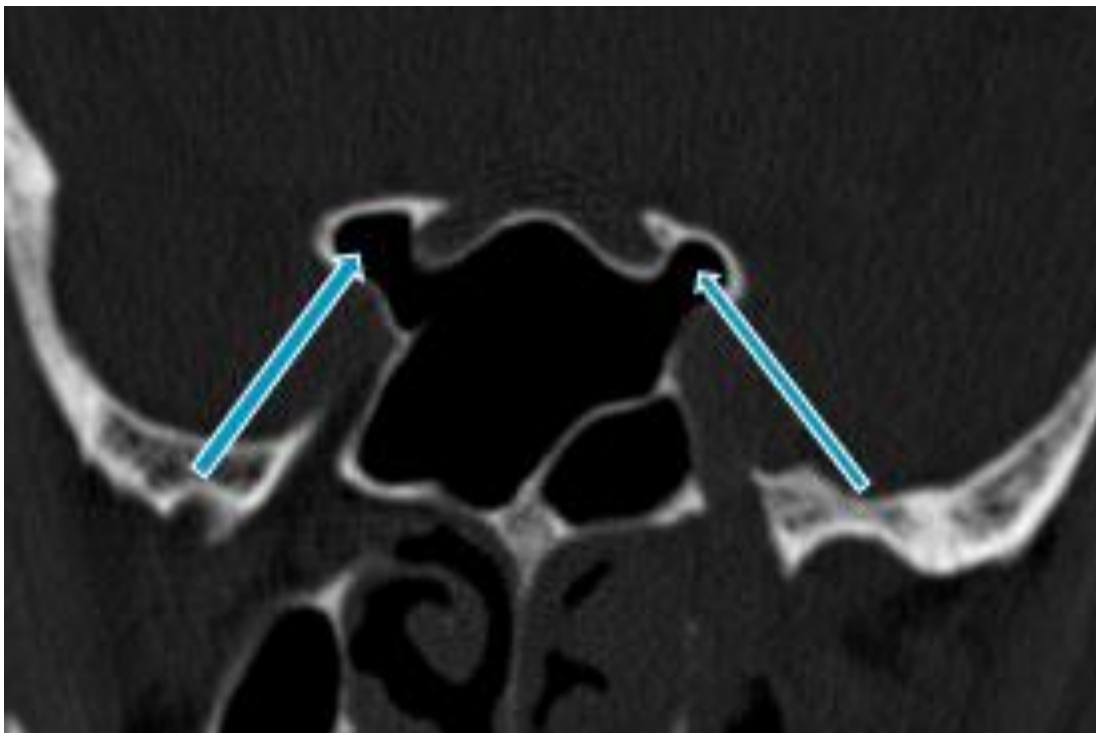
CT coronal section of sphenoid sinus showing pneumatization of both anterior clinoid processes.
